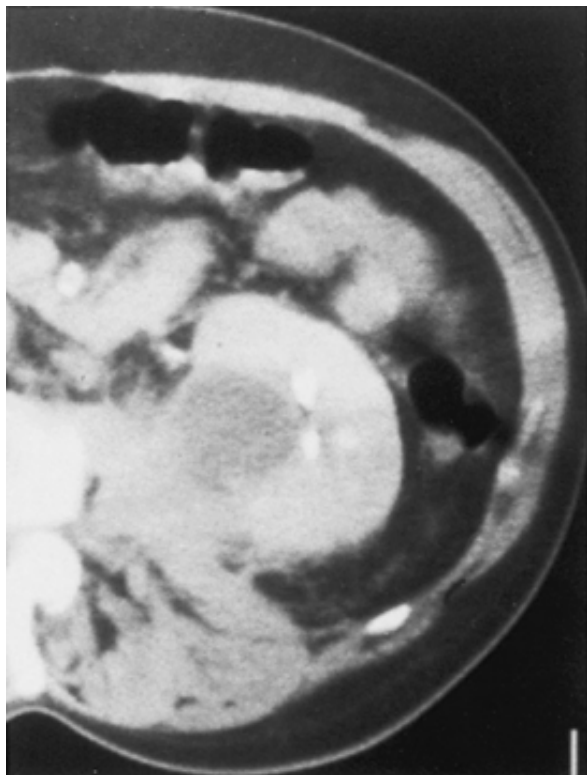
Computed tomography scan shows a cystic appearing lesion with debris. Puncture of the lesion confirmed the presence of a renal abscess. A drainage tube was subsequently placed inside the cavity as a therapeutic measure.
